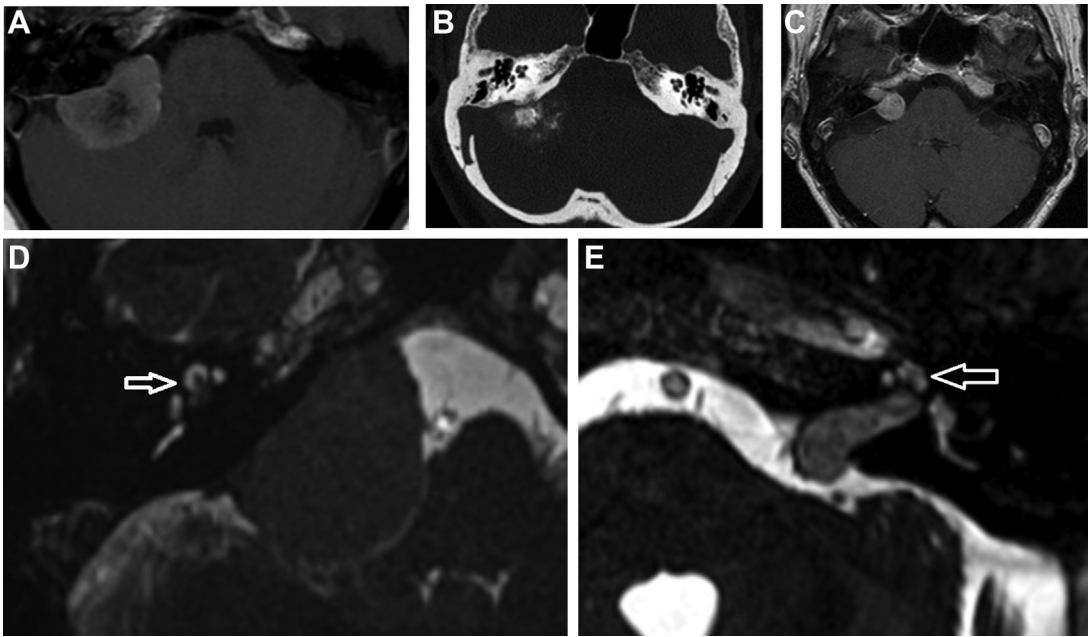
CPA meningioma imaging differential diagnosis. (A) Post-gadolinium T1w axial image of a meningioma reveals the broad base along the posterior petrous pyramid and its location eccentric to the IAM with (B) calcification on CT. (C) Post-gadolinium T1w axial images showing meningeoma with intracanalicular extension. Note how perilymphatic signal is preserved on CISS sequences when there is IAM extension from a (D) meningioma, whereas it may be reduced with an (E) VS (arrows).
